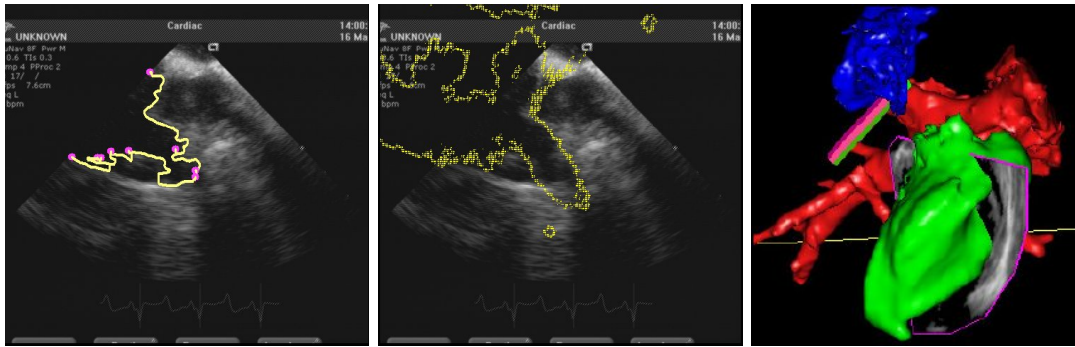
Contour of a cardiac chamber manually segmented from ultrasound (left). The contour of the same chamber segmented from the cardiac C-arm CT image and projected to the registered ultrasound image (middle). A fusion of an ICE image with segmented cardiac chambers from the 3D cardiac C-arm CT image (right). From [65]
